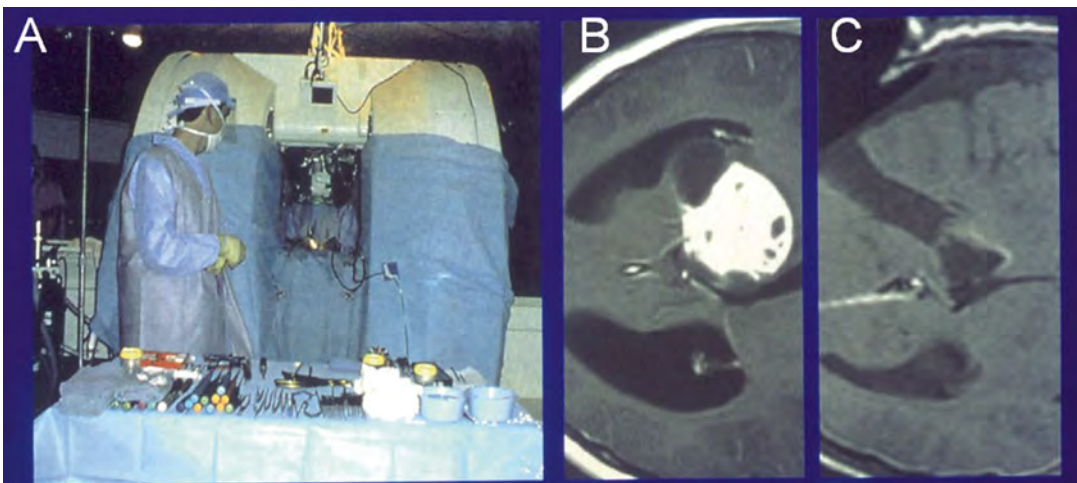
Intraoperative MRI (a) can be used to obtain better extent of resection safely. Preoperative axial T1 post-gadolinium MRI shows a large deep thalamic tumor (b), which was totally resected under guidance of intraoperative MRI (c)
